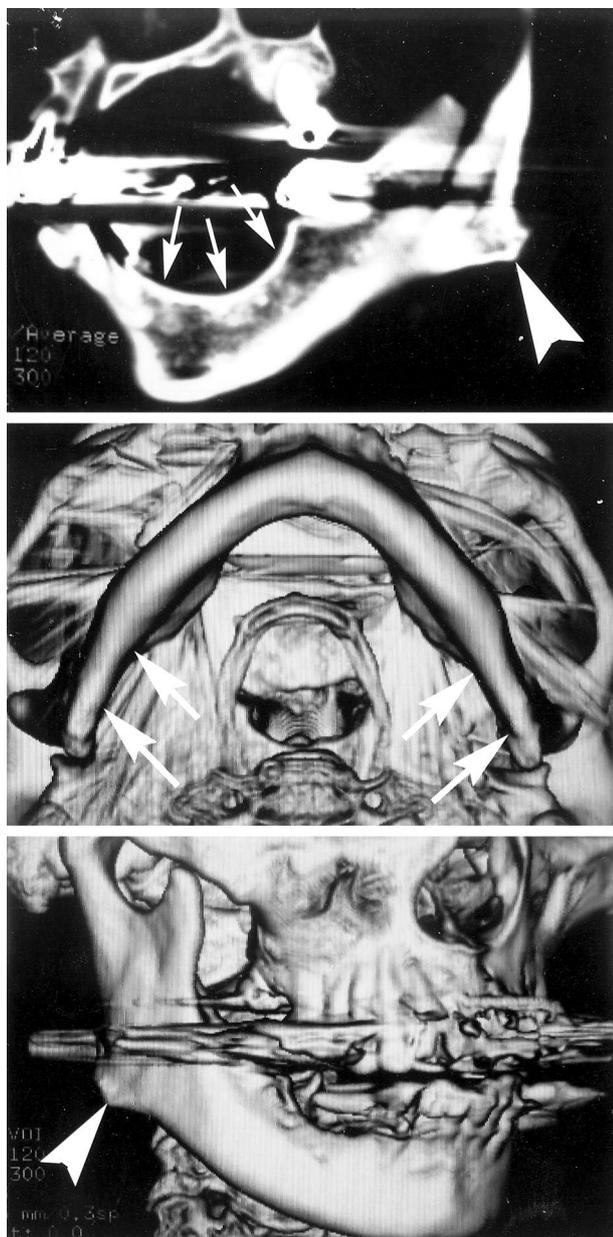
Computed tomographic scans of the edentulous mandible of a 69-year-old woman. (Above) Computed tomographic scan of the oblique plane of the left mandibular angle. Note the lateral flaring of the angle (arrowhead) even though the mandibular body shows remarkable atrophy (arrows) resulting from the extraction of the molars and premolars. (Center) A caudal view of the mandible by three-dimensional computed tomographic scan shows atrophy around the angle (arrows). (Below) An oblique view of the mandibular angle by three-dimensional computed tomographic scan. The lateral flaring is obviously noted (arrowhead).
